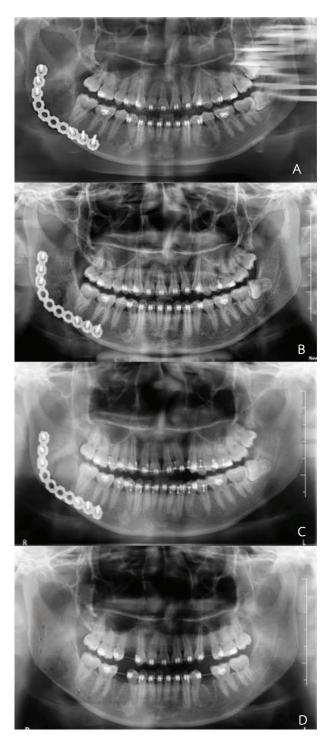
shows postoperative panoramic radiographs. (A) 3 months after surgery (B) 6 months after surgery (C) 12 months after surgery (D) after reconstruction plate removal
